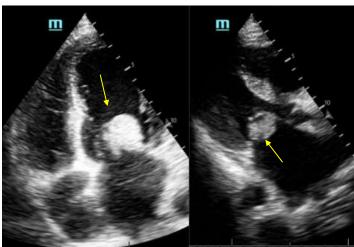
(Left) Point-of-care transthoracic echocardiogram in the apical four-chamber and (right) parasternal long-axis views demonstrating a large mitral valve vegetation (arrow).
